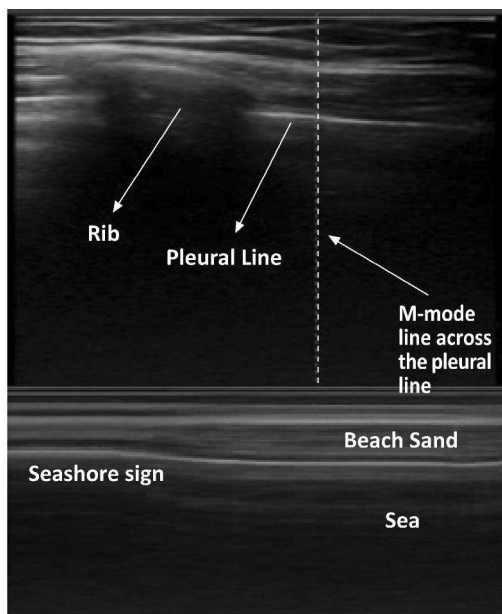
The top part of the picture with a linear probe shows a rib with the pleural line on the side. The M-mode of the ultrasound is then activated in this position, and below that we received an M-mode image of a 'seashore sign' which is normal and represents no pneumothorax.
